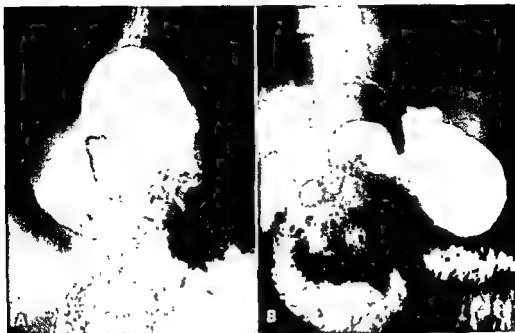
A, X-ray of upside-down stomach in large para-esophageal hernia. B, X-ray after gastropexy.
